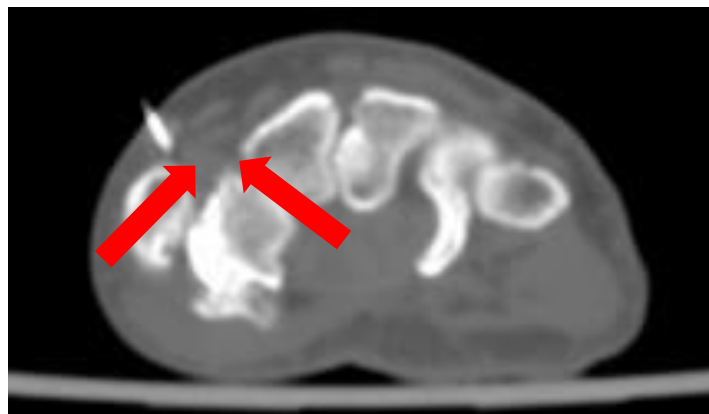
The first treatment is performed with CT guidance to identify the trapezium and base of the first metacarpal correctly. The infiltration point is marked with a dermographic pencil. Using CT, it is possible to verify the correct positioning of the needle (arrows).
